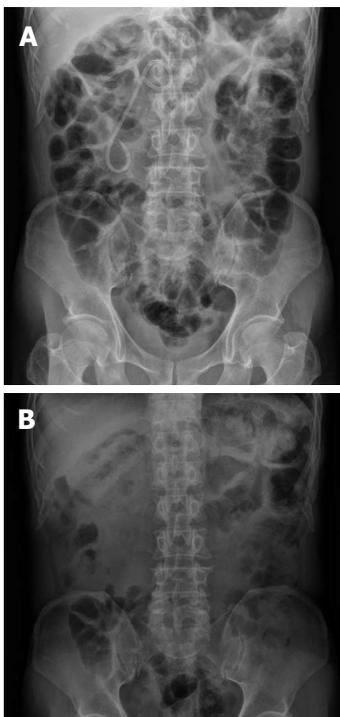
Plain abdominal radiography revealed double pigtail stent to efferent loop (A) and no double pigtail stent and other specific finding (B).
